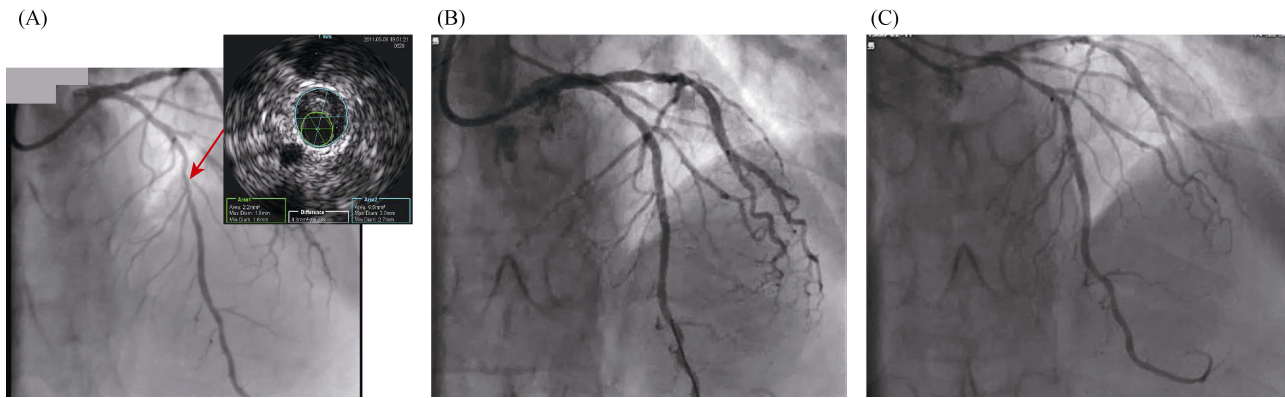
Coronary angiography results of the LAD. (A): IVUS results of stenosis indicated by red arrow; and (B & C): coronary angiography in 2011 post stent & in 2014. IVUS: intravascular ultrasound; LAD: left anterior descending coronary artery.
